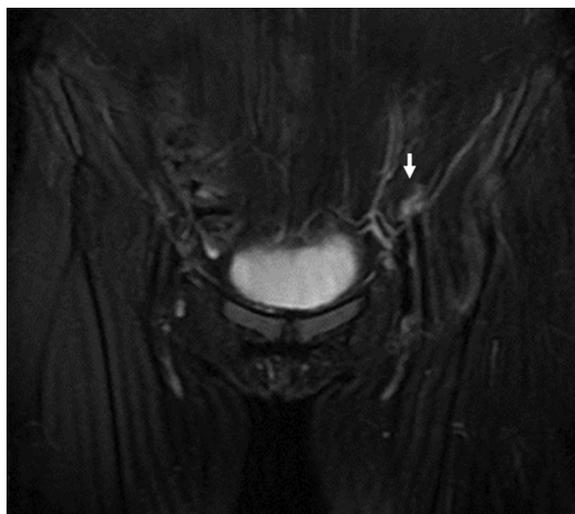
Coronal view of fluid-sensitive MRI showing a high-intensity lesion in the left rectus femoris (arrow).
